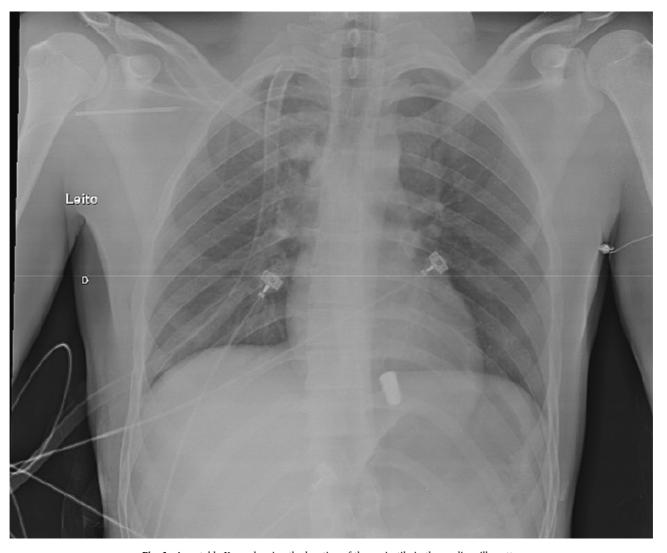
A portable X-ray showing the location of the projectile in the cardiac silhouette.
